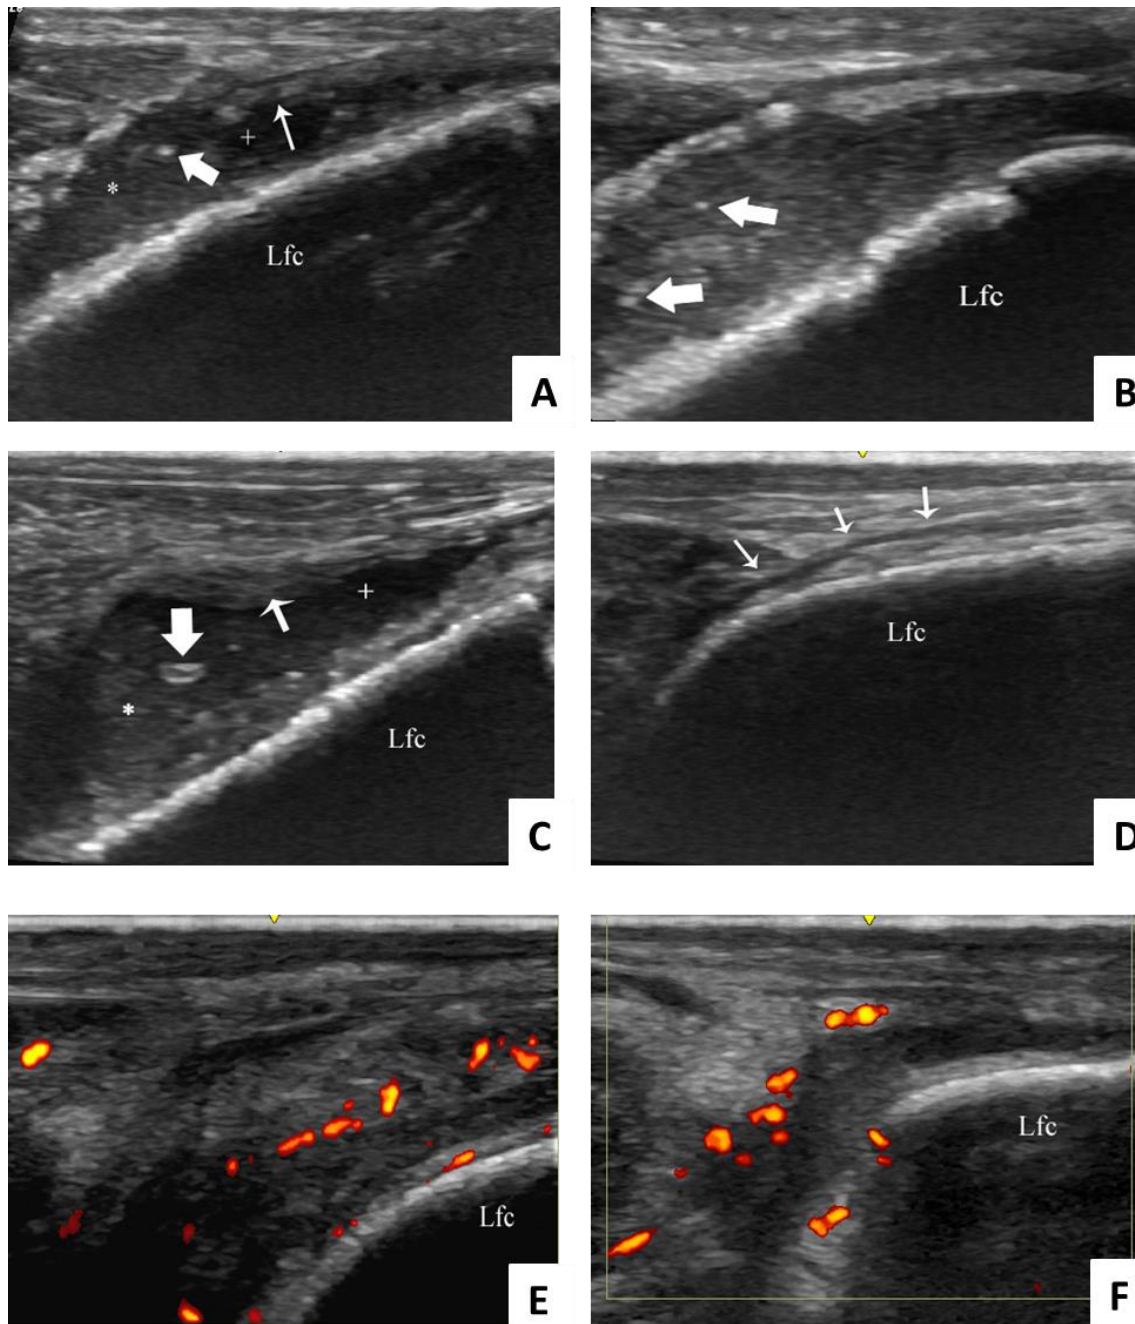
Ultrasound images of the lateral recess of rabbit knee joints. (A-C) Monosodium urate crystal-injected rabbit knees (A) Increased synovial fluid (+), synovial thickening (thin arrow), sand-like material (*) and a bright focus (thick arrow). (B) Bright foci (thick arrows) inside sand-like material. (C) Increased synovial fluid (+), synovial thickening (thin arrow), sand-like material (*) and a hyperechoic aggregate (thick arrow). (D) Lateral recess of a healthy control rabbit knee (arrows). (E, F) Power Doppler-flow signal of an arthritic synovial tissue. Lfc = lateral femoral condyle.
